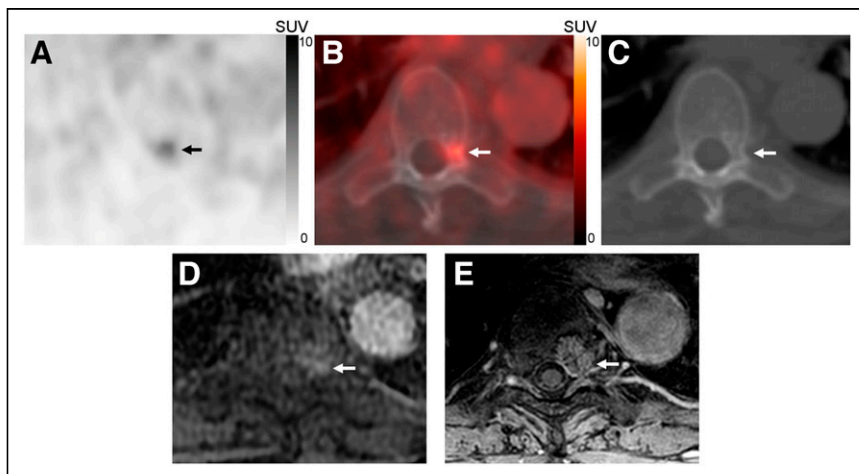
A 73-y-old patient with BCR PCA and PSA of 4.9 ng/mL. Axial ^{18}F -DCFPyL PET (A), ^{18}F -DCFPyL PET/CT (B), CT (C), pre-PSMA MRI (D), and follow-up MRI (E) images show a single area of subtle PSMA-avid uptake with SUV_{max} of 3.3 in left T8 lamina and subtle sclerotic CT features (arrows). This IBL became more prominent and enhanced over a 3-y period between retrospective MRI (D) and follow-up MRI (E) and was determined to be malignant.
